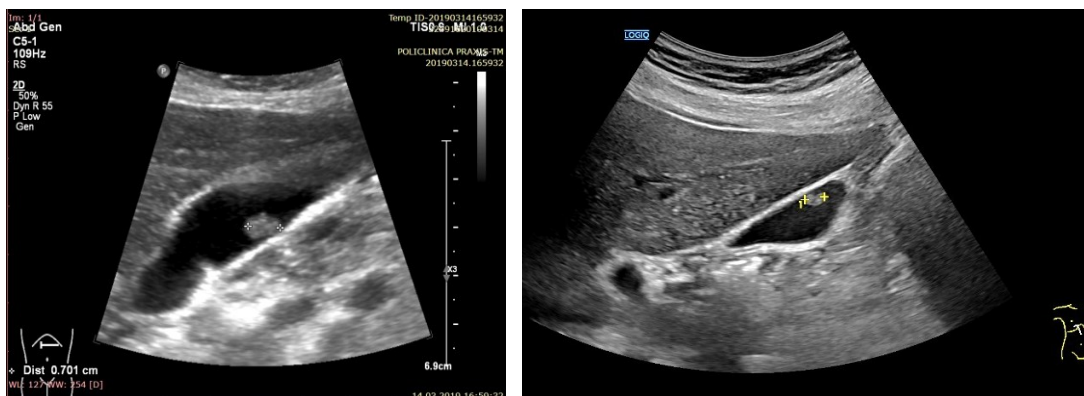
a, b. Ultrasound evaluation of the gallbladder showing a benign adenoma of approximately 7 mm
